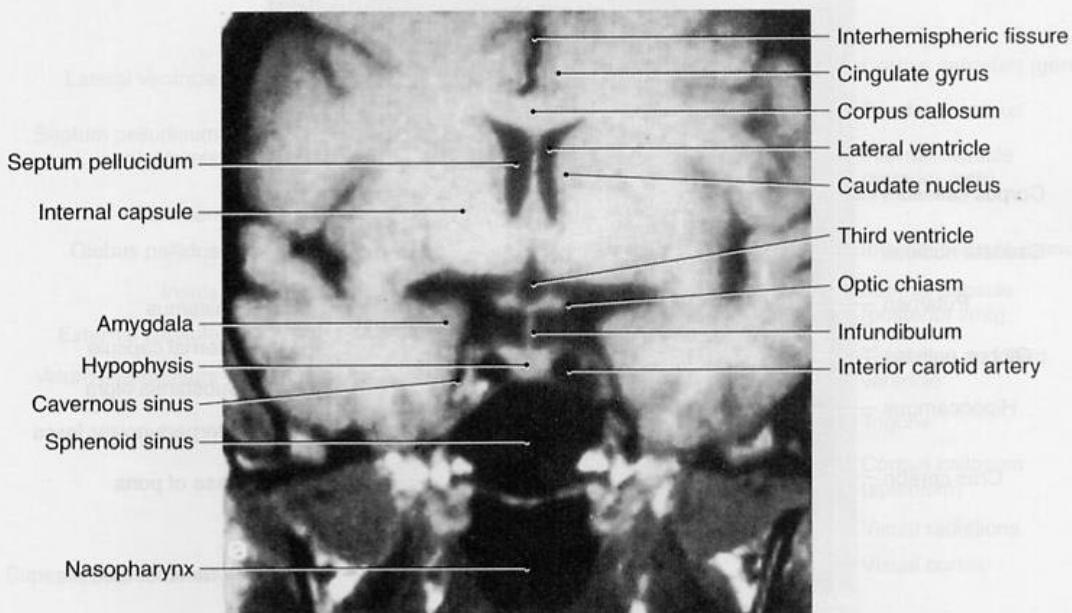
Coronal magnetic resonance imaging section through the amygdala, optic chiasma, infundibulum, and internal capsule. The cavernous sinus encircles the sella turcica and contains the following structures: cranial nerves (CN) III, IV, VI, V-1, and V-2; postganglionic sympathetic fibers; and the internal carotid artery. This is a T1-weighted image.
